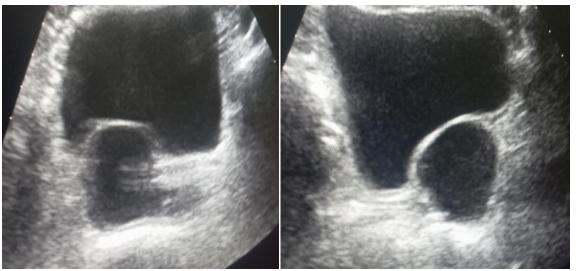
Transabdominal ultrasound image showing a well-defined anechoic cystic structure in the right pelvis, adjacent to the bladder
